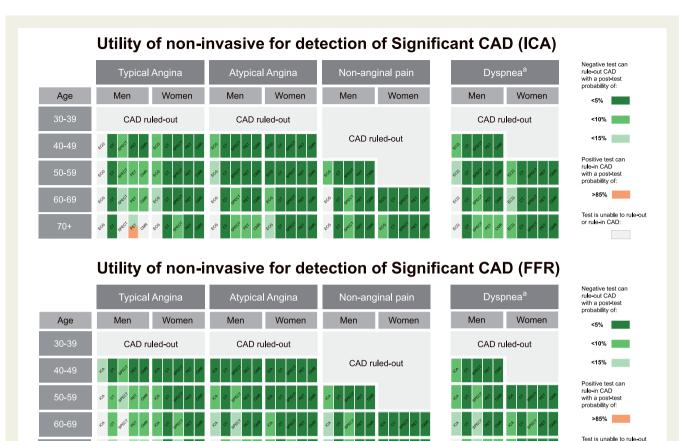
Updated *diagnostic technique selection tool* for all patient categories based on sex, age, and type of chest pain, considering both ICA (upper panel) and FFR (lower panel) as the reference standard. The colour gradients inform the confidence with which a negative result can rule-out disease (i.e. by driving the *post-test probability* below 15, 10, or 5). CAD is directly rule-out with a PTP \leq 5. ^aThe categories corresponding to dyspnoea as the predominant or only symptom; CAD, coronary artery disease; CCTA, coronary computed tomography angiography; CMR, cardiac magnetic resonance; FFR, fractional flow reserve; ICA, invasive coronary angiography; PET, positron emission tomography; SPECT, single photon emission computed tomography. Adapted from Knuuti *et al.*¹⁰
